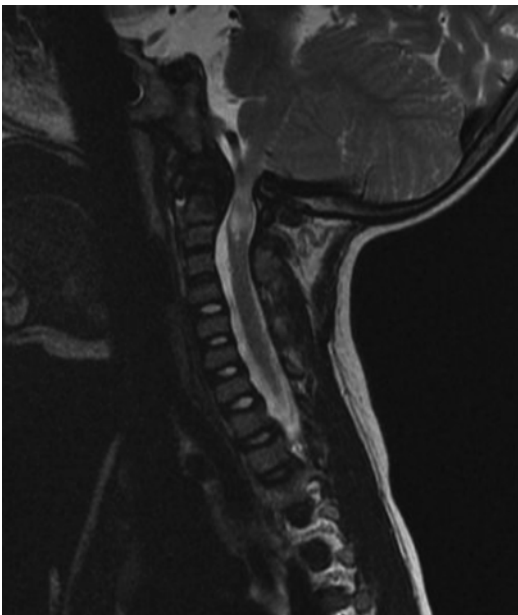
Foramen magnum stenosis in achondroplasia. The MRI showed significant cervical magnum stenosis with cervical myelopathy in a patient with achondroplasia
